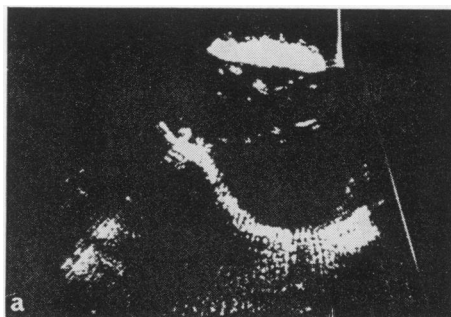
Ultrasonic scan of amoebic liver abscess.
